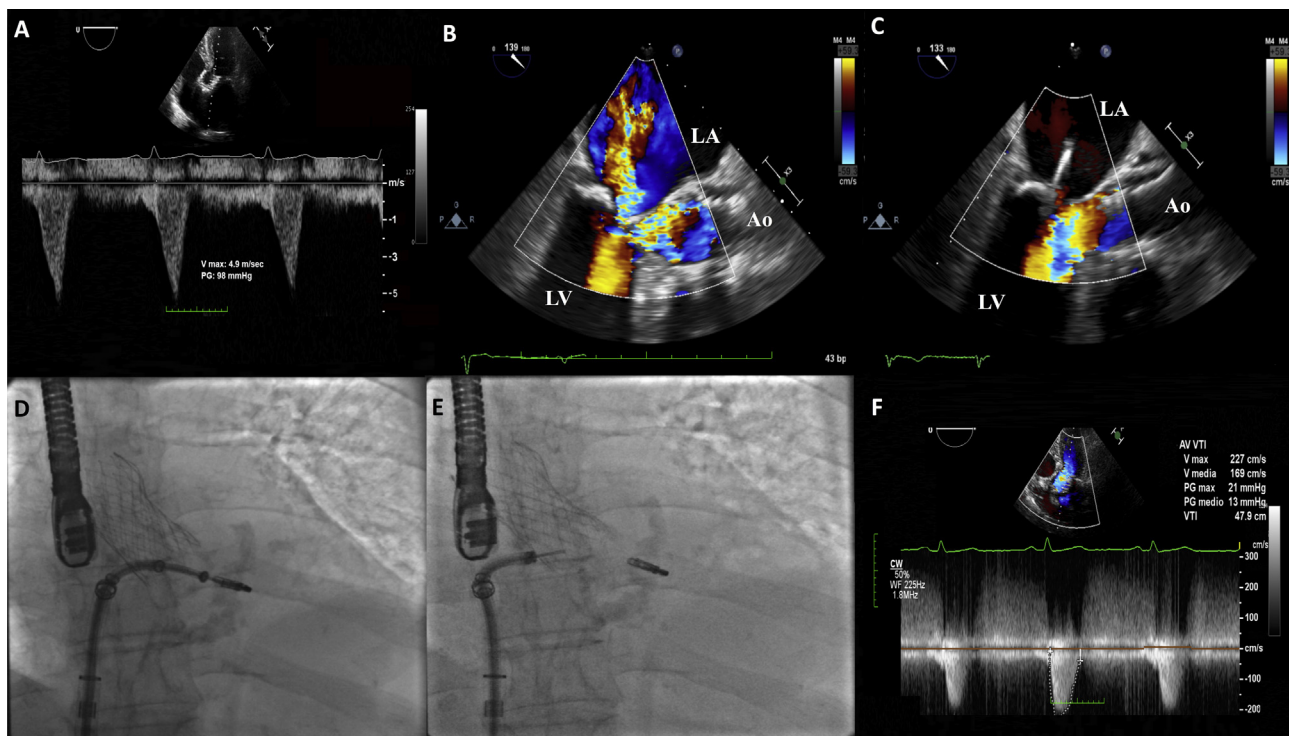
(A) Severe dynamic LV outflow tract obstruction (B) Severe mitral regurgitation with eccentric jet owing to systolic anterior motion (SAM) of the anterior mitral valve leaflet. (C) Successful grasping of mitral valve leaflets with disappearance of SAM (D, E) final grasping maneuvers and release of one single clip. (F) Doppler echocardiography showing low systolic velocities with absence of significant intraventricular gradients. (Ao = aorta; LA = left atrium; LV = left ventricle.)
